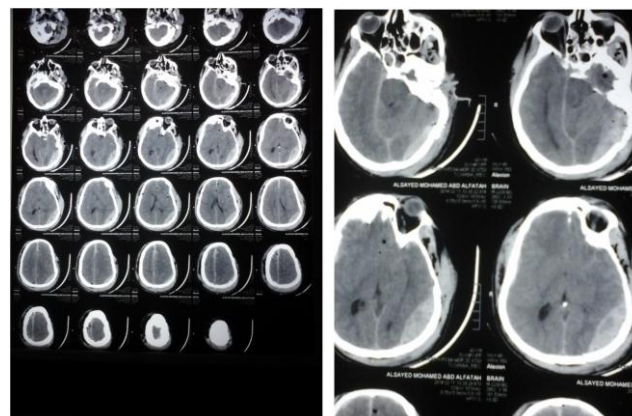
Pre-operative CT brain of Case 2
